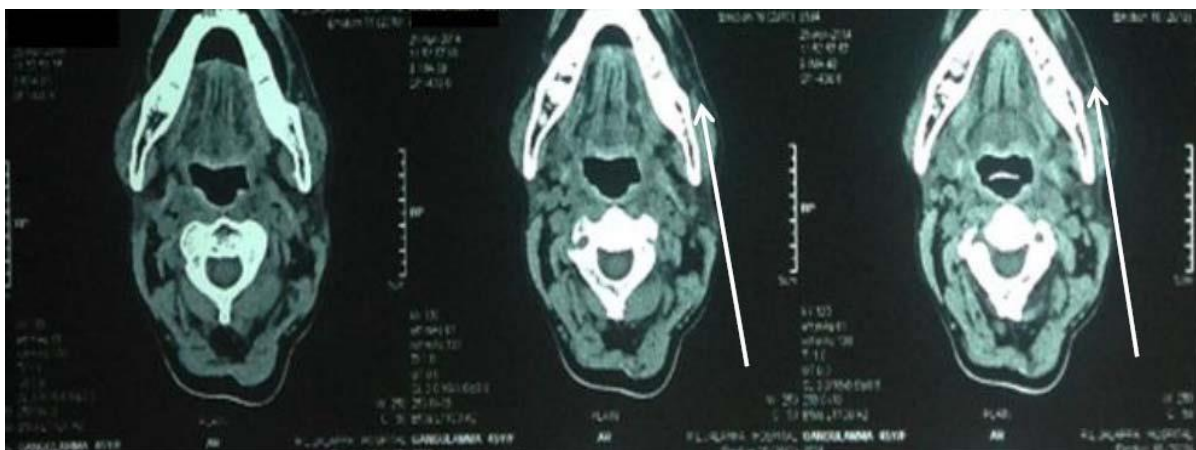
Post treatment CT scan showing reduction in tumor size, arrow pointing towards tumor site.
